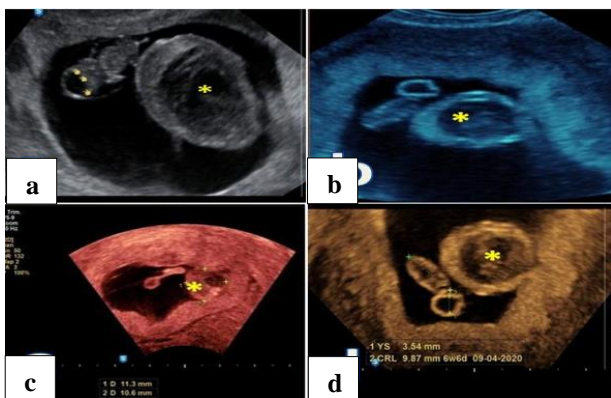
(a-d): CB by gray scale transvaginal ultrasound (2D-TVUS): rounded heterogeneous lesion protruded from the chorion into the gestational sac (astrix). CB is separable from the yolk sac and the fetal pole.
